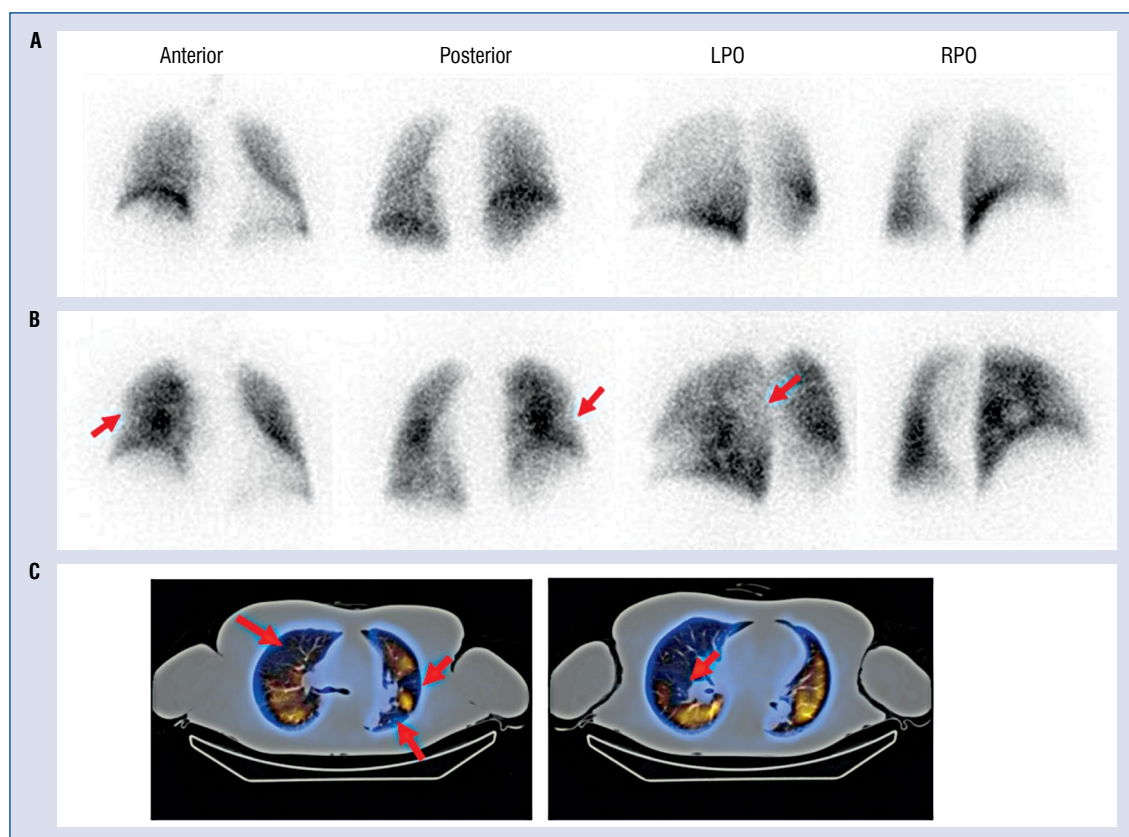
Ventilation/perfusion (V/Q) scans demonstrating pulmonary embolism. Moderate to large mismatch on V/Q scan: normal ventilation scan (A) and moderate-sized perfusion defect in right middle lung and large-sized perfusion defect in left upper lung on perfusion scan (B). A large-sized perfusion defect in right upper lung, and two, small-sized perfusion defects in left upper lung and a missed perfusion defect in anterior basal segment of right lower lung on perfusion planar image in perfusion single photon emission computed tomography-computed tomography (SPECT-CT; C); LPO — left posterior oblique; RPO — right posterior oblique.
